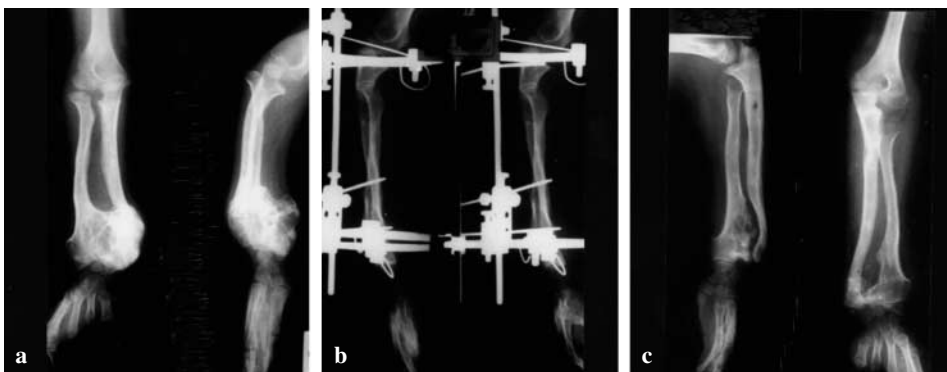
A 10-years-old boy (Case 3) with hereditary multiple exostosis, dislocated radial head at the right elbow and very large exostosis of the lower radius. a Postoperative anteroposterior and lateral radiographs. b Postoperative view at the end of distraction and exostosis removal. c Radiographs at the 2-year follow-up showing overlengthening of the ulna
